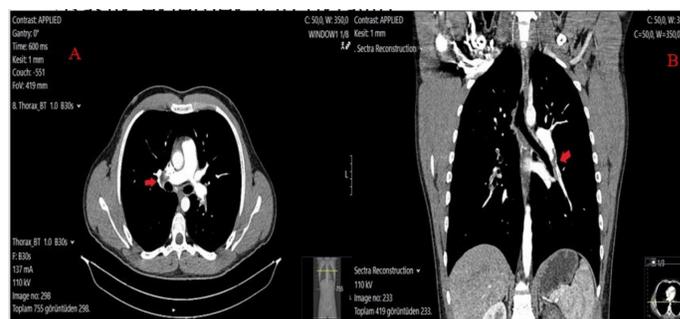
Computed tomography pulmonary angiography indicated a filling defect compatible with acute stage thrombus allowing flow in the right main pulmonary artery. (A) filling defect compatible with thrombus was observed in the right and left pulmonary arteries at the segmental level (B)
